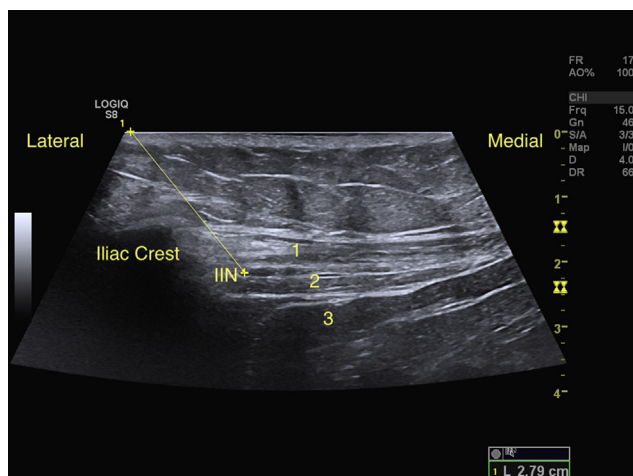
Lateral decubitus ultrasound image with in-plane target line demonstrated. Note the shallower angle compared with that in the supine position and the reduced depth to target. IIN = ilioinguinal nerve; 1 = external oblique muscle; 2 = internal oblique muscle; 3 = transversus abdominis muscle.
